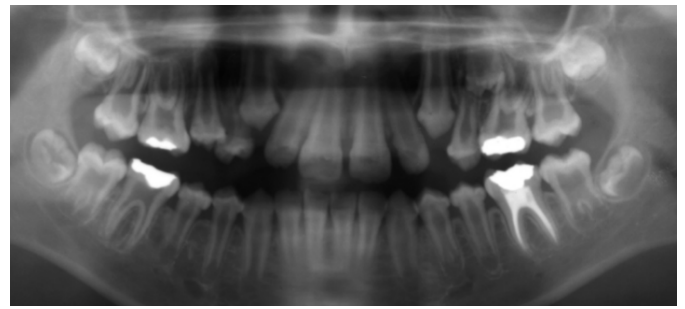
A panoramic X-ray of a 12-year-old child with HPP (19). This X-ray shows large pulpal chambers, abnormalities of crown shape. The second molars show taurodontism more severe than the first molars
